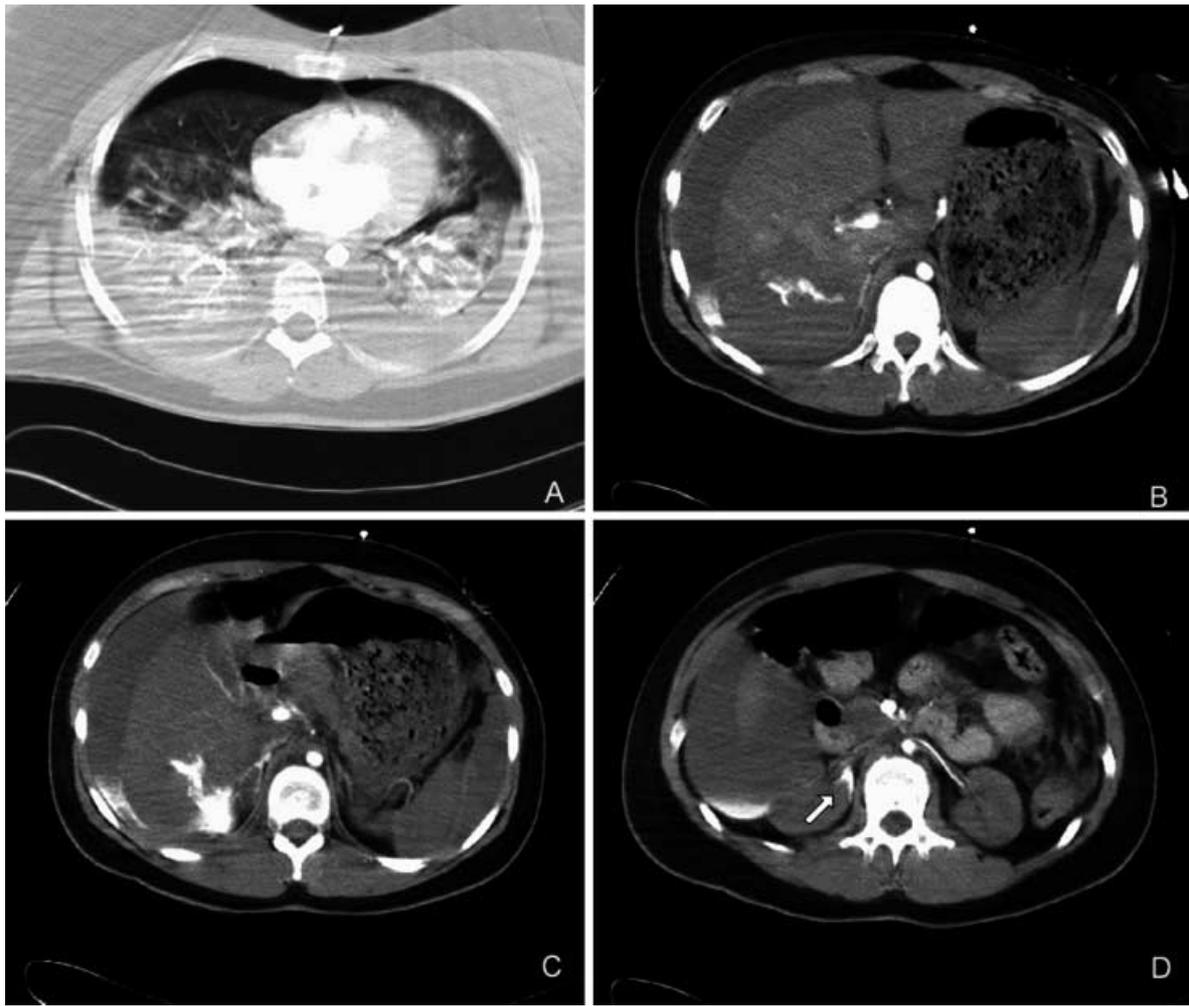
Clinically urgent emergency patient with suspected multiple trauma as a pedestrian involved in a car accident and underwent fast spiral CT. Combined injuries were detected. a Bilateral hematothorax with atelectasis, bilateral lung contusions and lung lacerations. A ventral pneumothorax was not detectable on the initial plain film of the chest. b, c A centrally located liver parenchyma laceration in the right liver lobe which extends to the liver capsule. There are at least two sites of contrast medium extravasation representing active arterial bleeding sites leading to a large subcapsular hematoma and intra-abdominal blood deserving immediate surgical therapy. d An additional dorsal subcapsular bleeding of the right kidney (*arrow*). Note the small diameter of the abdominal aorta as a sign for centralization of the circulation and shock
